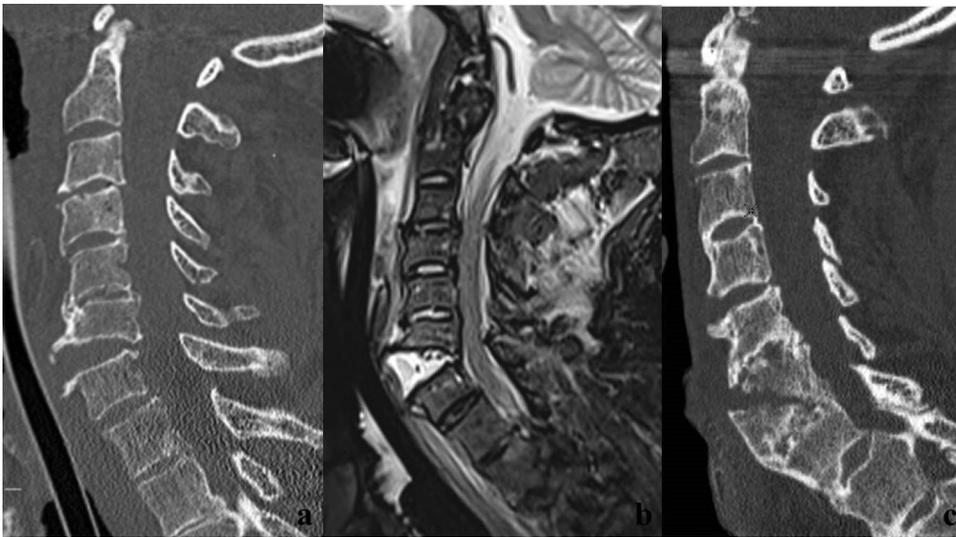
(a–c) A 72-year-old man slipped in the bathroom with facial trauma and neck hyperextension (a and b). Midline reformatted CT image (a) showing a marked enlargement of C6–C7 anterior intervertebral disc, along with posterior displacement of C6. A disc angle greater than 18° on CT is concerning for anterior cervical disco-ligamentous injury and indicates a MRI evaluation. On MR, the disc injury appears as asymmetric widening of an isolated disc space along with focal signal changes, often extended to contiguous other damaged soft tissues. Axial CT sequence (not shown) excluded impaction fractures involving posterior arc elements. Hyperextension fractures prevail in the rigid spines. A 53 year-old man with AS after a fall from standing (c). Sagittal midline reformatted CT image showing a horizontal fracture starting from the vertebral body and extended to posterior fused facet joints.
